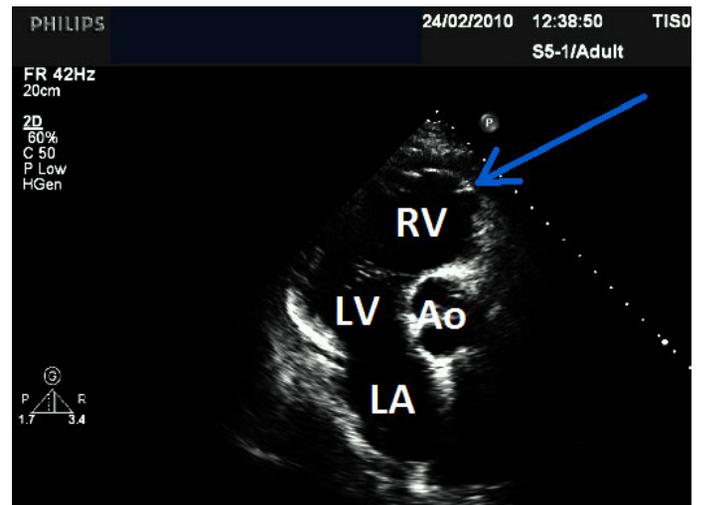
Transthoracic echocardiographic, parasternal long axis view used to visualize damage to the wall of the right ventricle (blue arrow) after transvenous lead extraction. LV, left ventricle; LA, left atrium; RV, right ventricle, Ao, aorta
